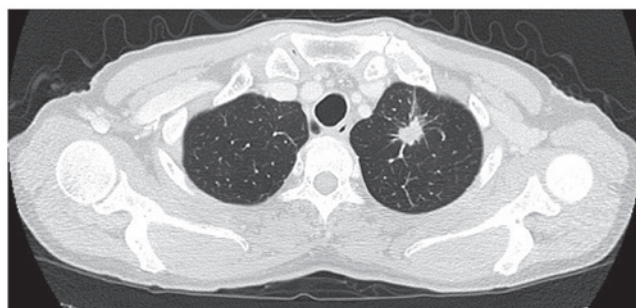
Chest computed tomography scan at the initial presentation revealed a mass in the upper lobe of the left lung with pleural fluid.
